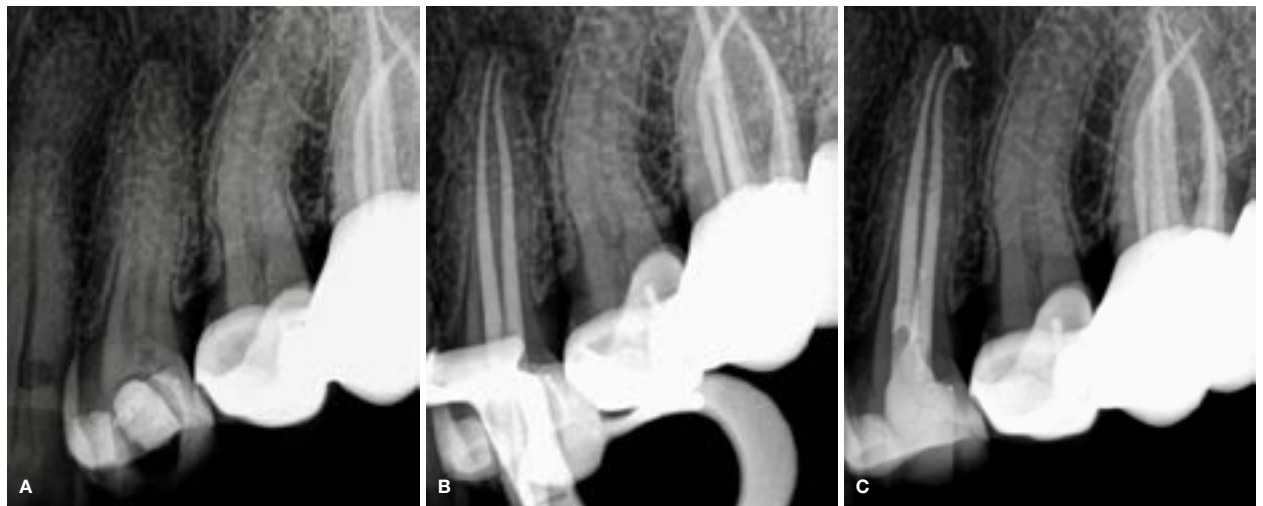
(A) Preoperative periapical radiograph of the maxillary left first premolar.
